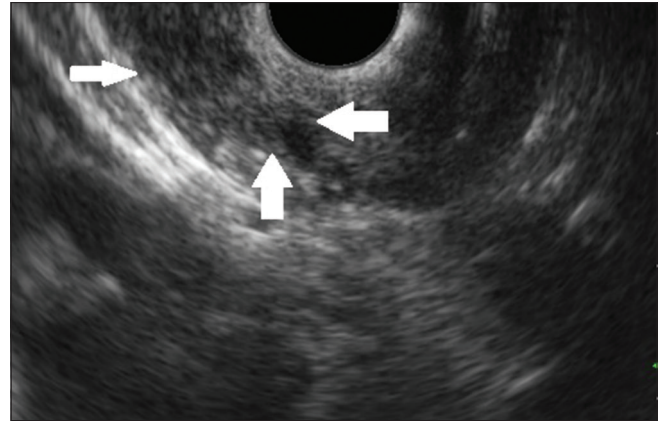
Endoscopic ultrasound: Enlarged perigastric lymph node
